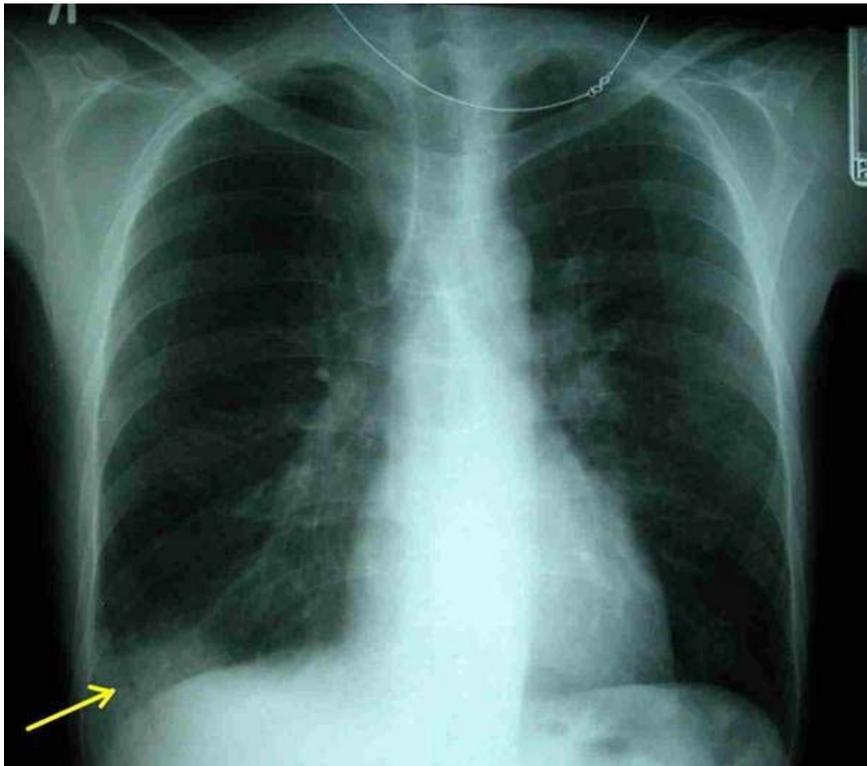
A posteroanterior chest radiograph showing a peripheral wedge-shaped infiltrate caused by pulmonary infarction secondary to pulmonary embolism. Hampton hump is a rare and nonspecific finding
